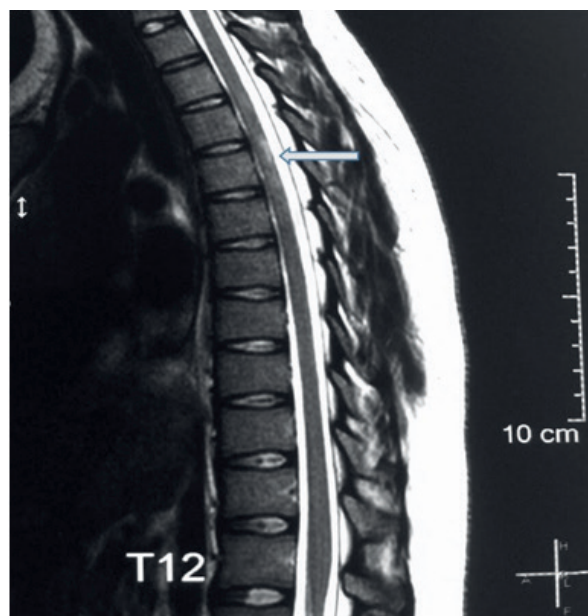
MRI of Thoracic Spine evidencing signal changes, affecting the posterolateral aspect of the central marrow, in the level of T4 (Arrow).
